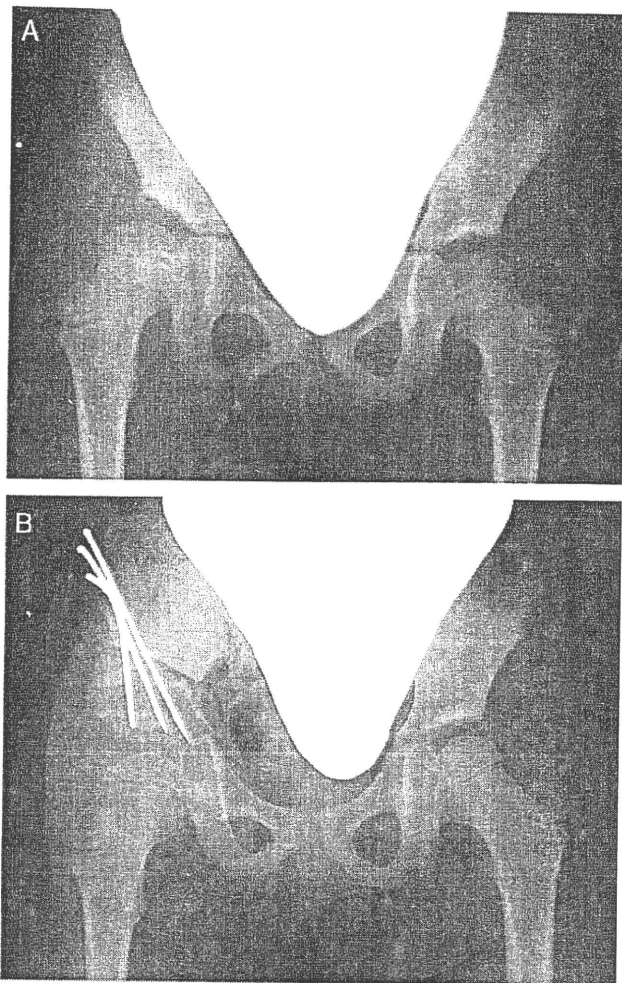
Anteroposterior radiographs of the pelvis of a 5-year-old girl with residual acetabular dysplasia of the right hip. Developmental dislocation of the right hip was conservatively reduced by overhead traction at the age of 10 months. Preoperative radiograph (A) indicated center-edge angle (CEA) of 1 degree, acetabular index (AI) of 33 degrees. Radiograph 5 weeks after surgery (B) showed CEA of 20 degrees and AI of 12 degrees. The distal fragment was rotated anterolaterally by the lateral rotation angle of 31 degrees, distance *d* of 6 mm, and the ratio of the obturator height of 67%. The center of the femoral head was moved 9 mm caudally and 3 mm medially after surgery.
